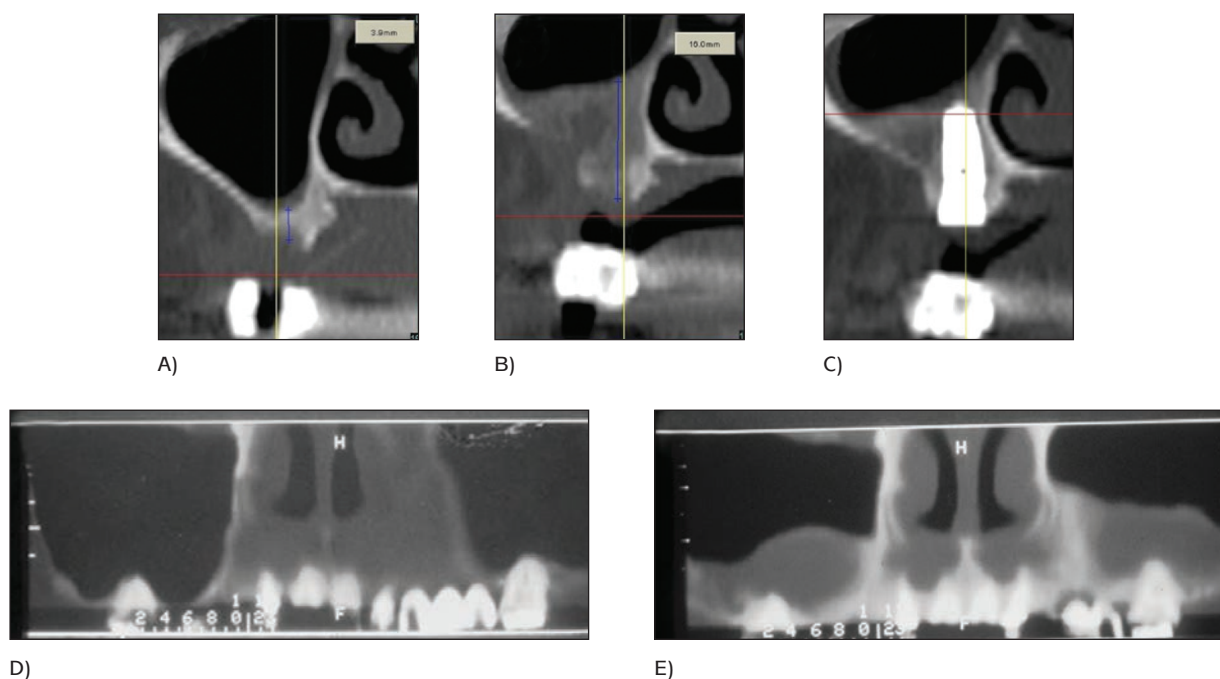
Representative CT scans from A) preoperatively (baseline), B) 6 months after treatment, and C) after dental implant placement in rhBMP-2/ACS subject. Bone height increased from 3.9 mm at baseline to 16.0 mm at 6 months postoperatively. D) Preoperative panoramic radiograph revealing deficient bone in posterior maxilla and E) panoramic radiograph 6 months after treatment revealing *de novo* bone formation.
